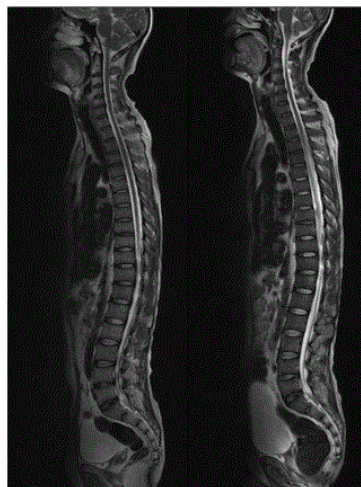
(a) Spine MRI 1day before Nelarabine start. No evidence of tumor invasion in cerebrospinal cavity. From T8 to T11, it might be T2 high signal intensity but it can be considered as artifact. (b) Spine MRI 16 days after Nelarabine start and 3 days after he complained both leg paralysis and sensory loss. High SIs in dorsal column of T2-T11 and anterior column of T4-7 with diffuse cord swelling.
